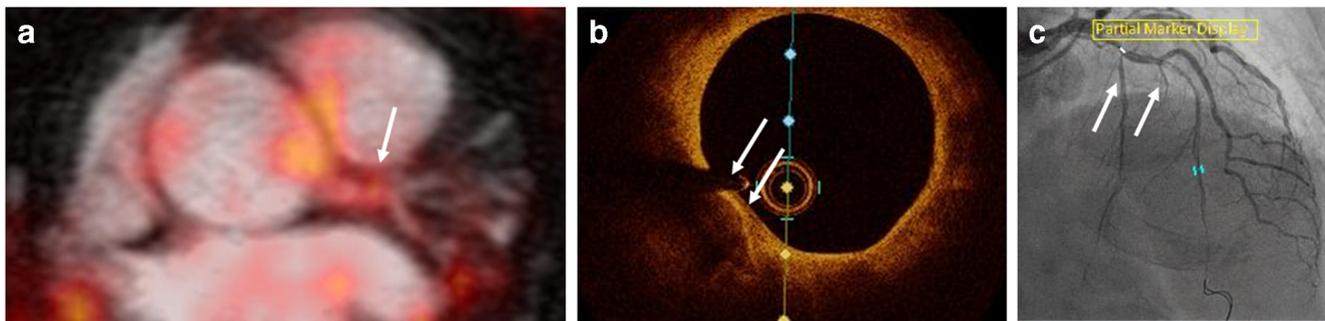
18F-sodium fluoride (18F-NaF) gadovist enhanced hybrid PET/MR image using Siemens Biograph. a Moderately increased uptake of 18F-NaF in distal left main artery (white arrow). b Corresponding optical coherence tomography showed a mixed plaque with calcification (white
